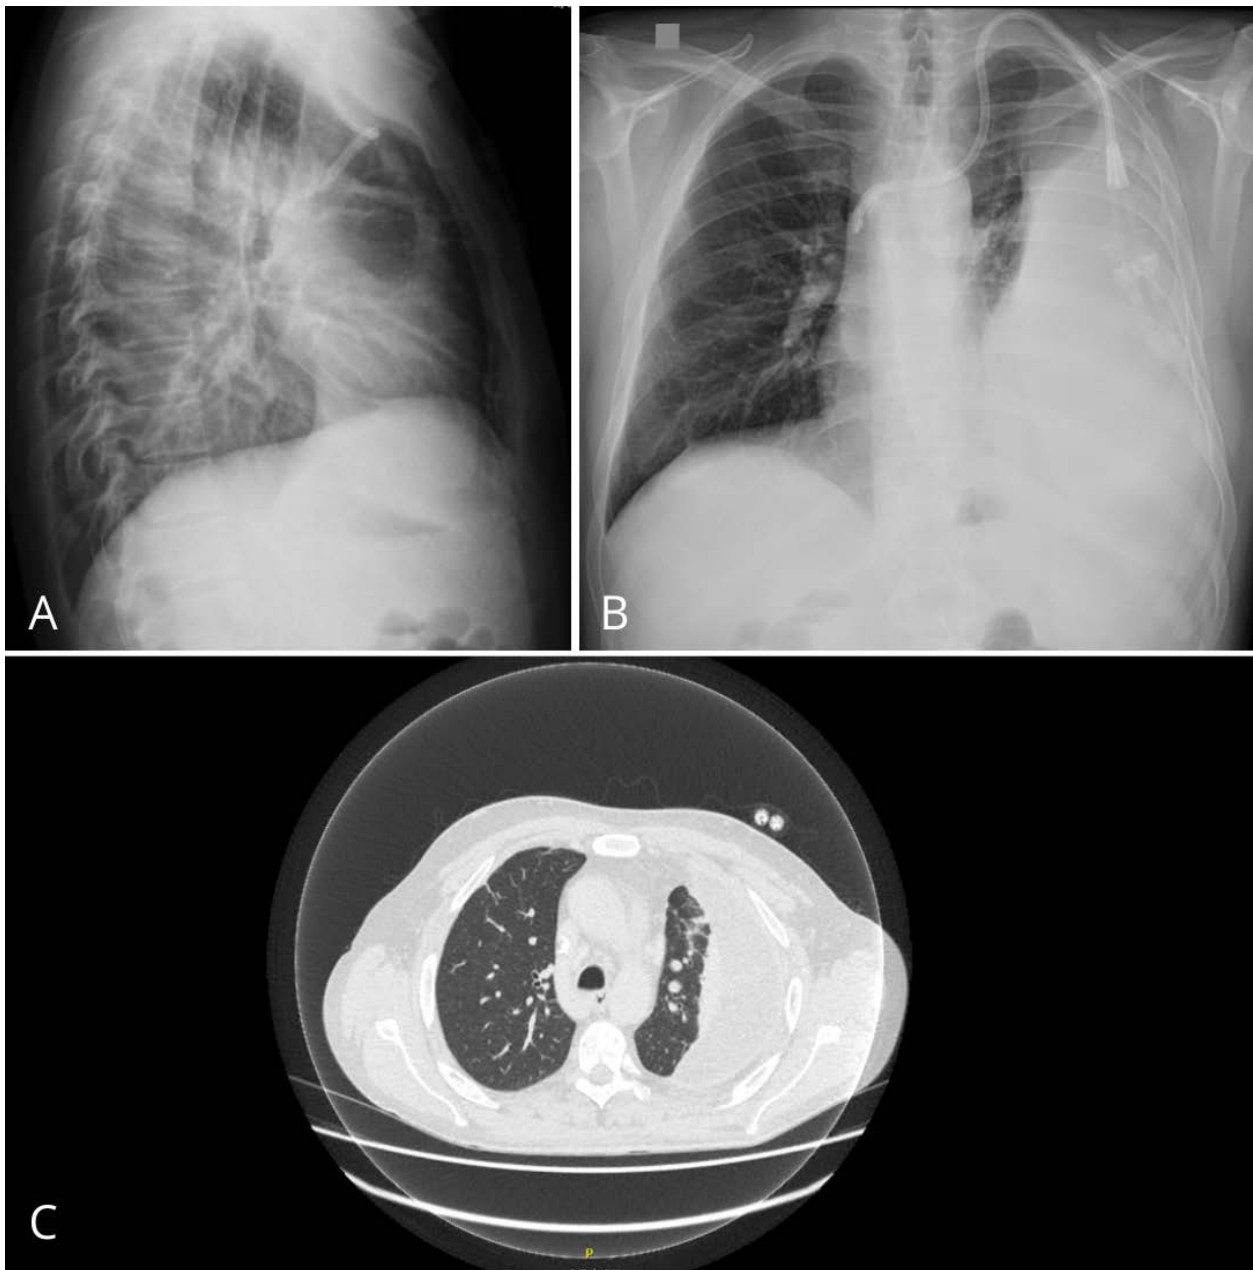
(A) Lateral chest radiograph showing pulmonary retraction to the left. (B) Posteroanterior chest radiograph with consolidated pleural effusion on the left. (C) Computed tomography showing left pleural effusion and atelectasis due to adjacent compression.
